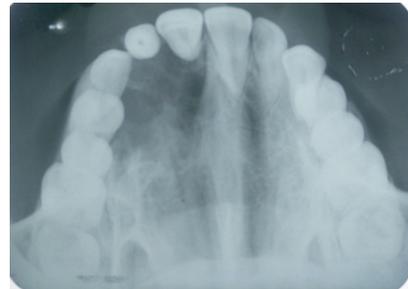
Occlusal radiograph showing ill-defined mixed radiolucent and radiopaque lesion involving right anterior maxilla extending upto 14 with expansion of labial cortical plate and displacement of root of 11, 12 and 13 labially. Faint internal septation give partial locular appearance to the lesion.
